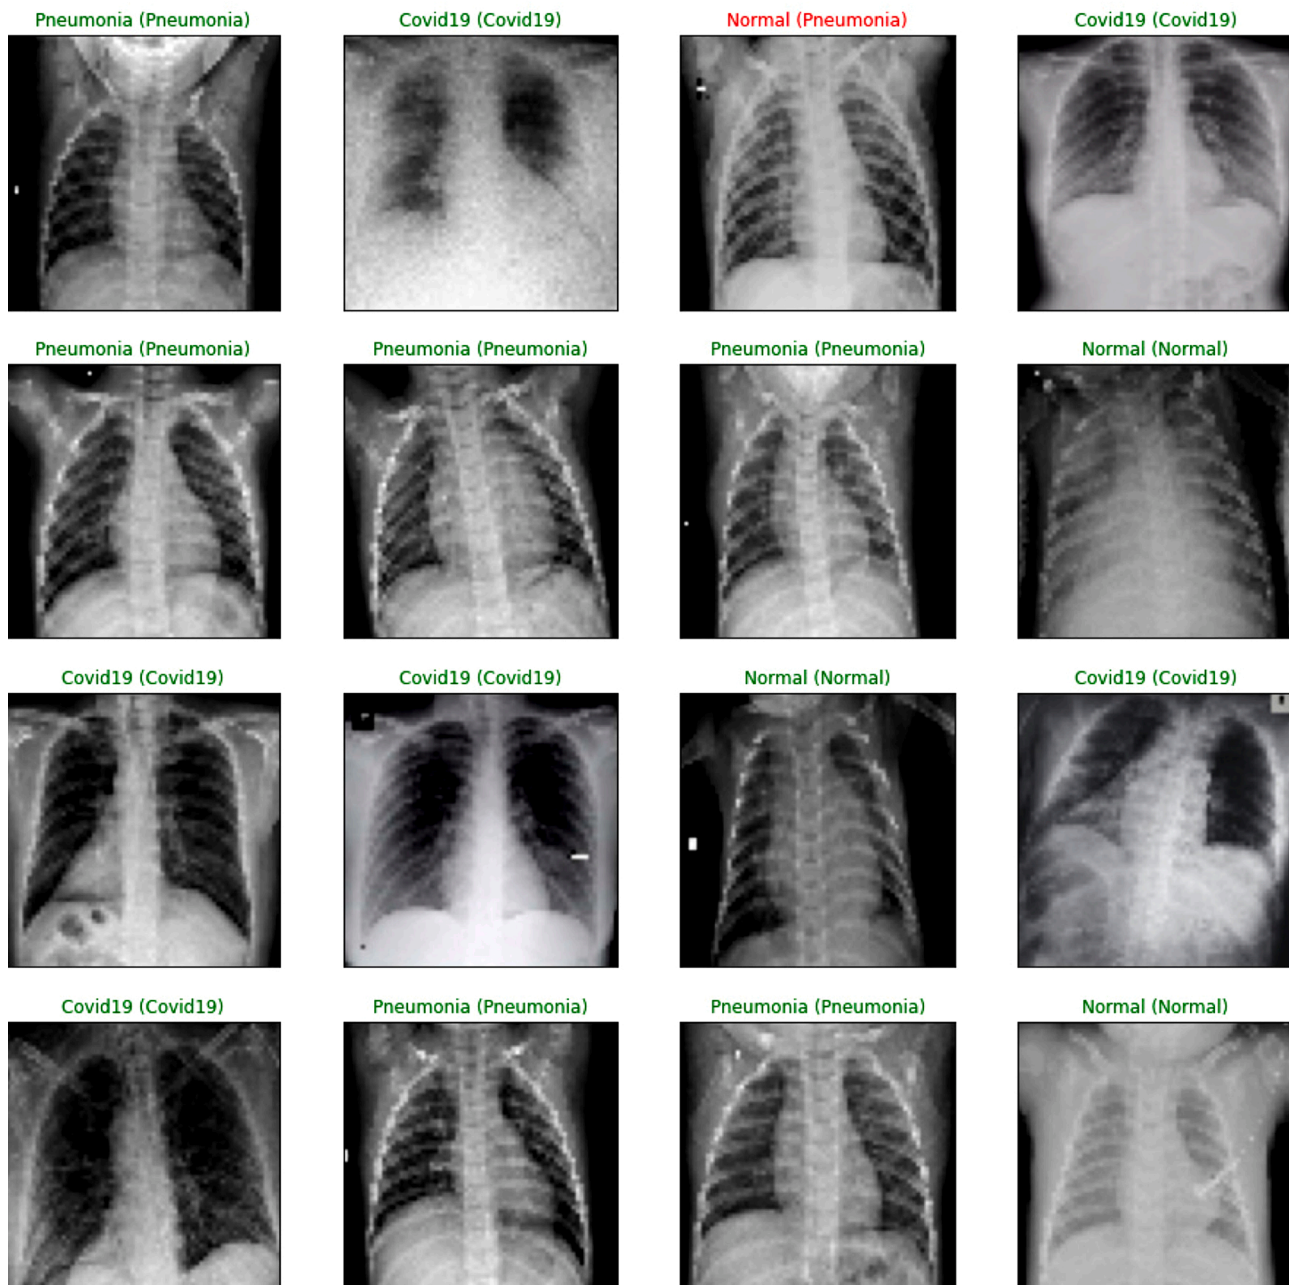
X-ray image detection with the proposed COVID-DeepNet model.
